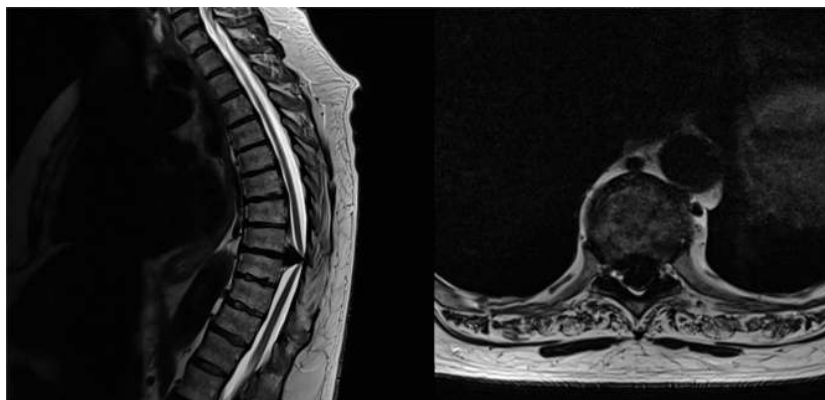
Sagittal and axial T2-weighted MRI demonstrating spinal cord compression from a large thoracic disc at the T8-9 level.
